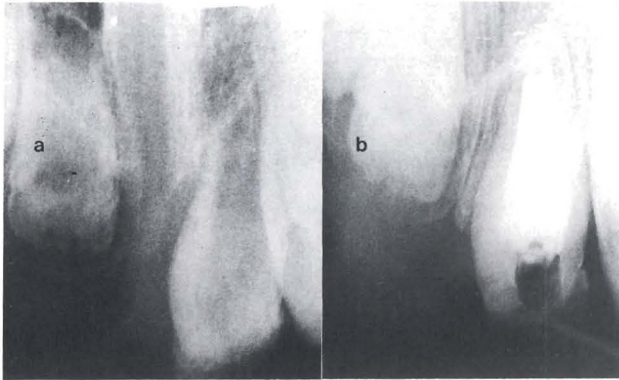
X-ray appearance of erupting, abscessed "ghost tooth". Note substantial root development and wide-open apex. Figure 8b. Same tooth 3 months after apexification and completion of root canal therapy.
